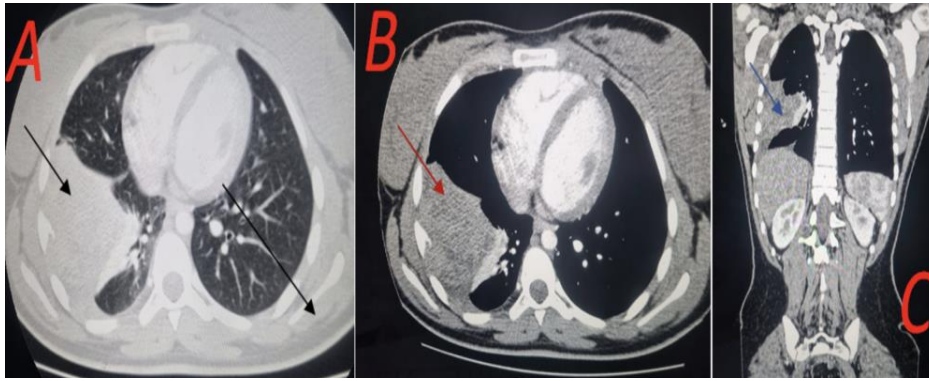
(A) : Parenchymal CT Section Showing A Right-Sided Pleural Mass Black Arrow (B) : Mediastinal CT Section Revealing The Pleural Mass In The Right Chest (Red Arrow) Without Associated Mediastinal Adenopathy. (C) Coronal chest CT Scan Revealing The Right-Sided Pleural Mass (Blue Arrow) With Heterogeneous Enhancement After Contrast Injection
